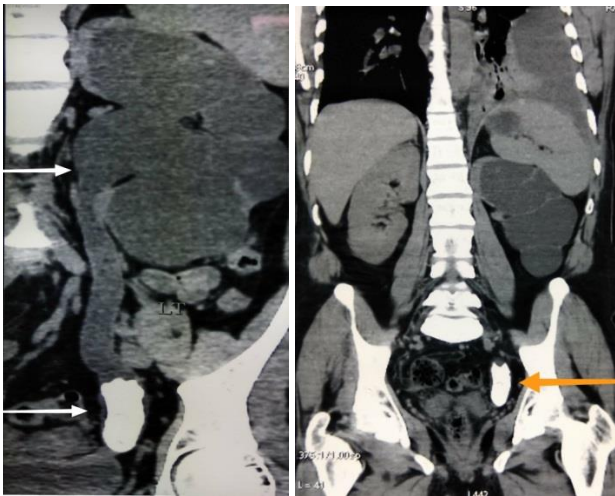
(A and B): A CT scan of abdomen showing a 45 mm calculus in the left vesico-ureteric junction with dilated left ureter and gross hydronephrosis of left kidney.
